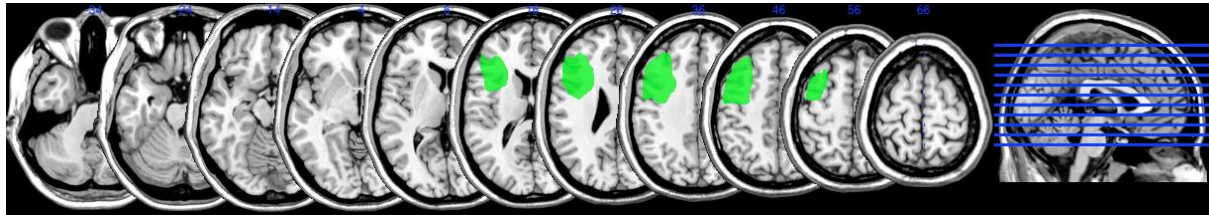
MRI scan of patient LC
